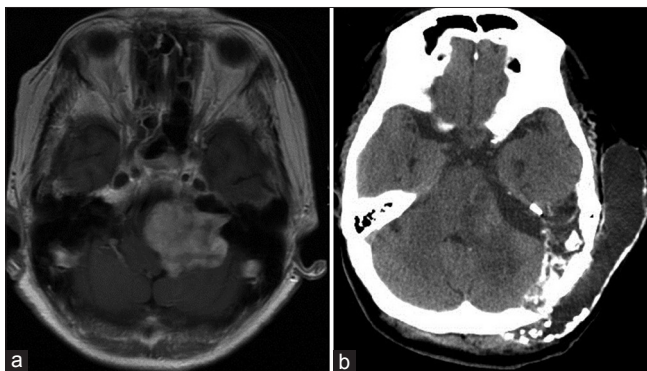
(a) Contrast axial T1-weighted brain MRI showed a large left CP angle acoustic neuroma with brain stem compression. (b) The axial brain CT showed left periauricular pseudomeningocele 2 weeks after the operation
